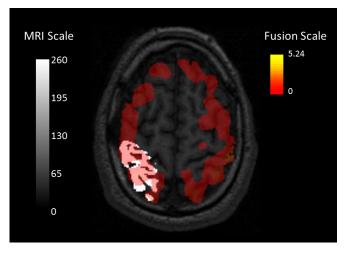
Axial section of the fusion image from PISCOM analysis and the theoretical focus coregistered with MRI.
